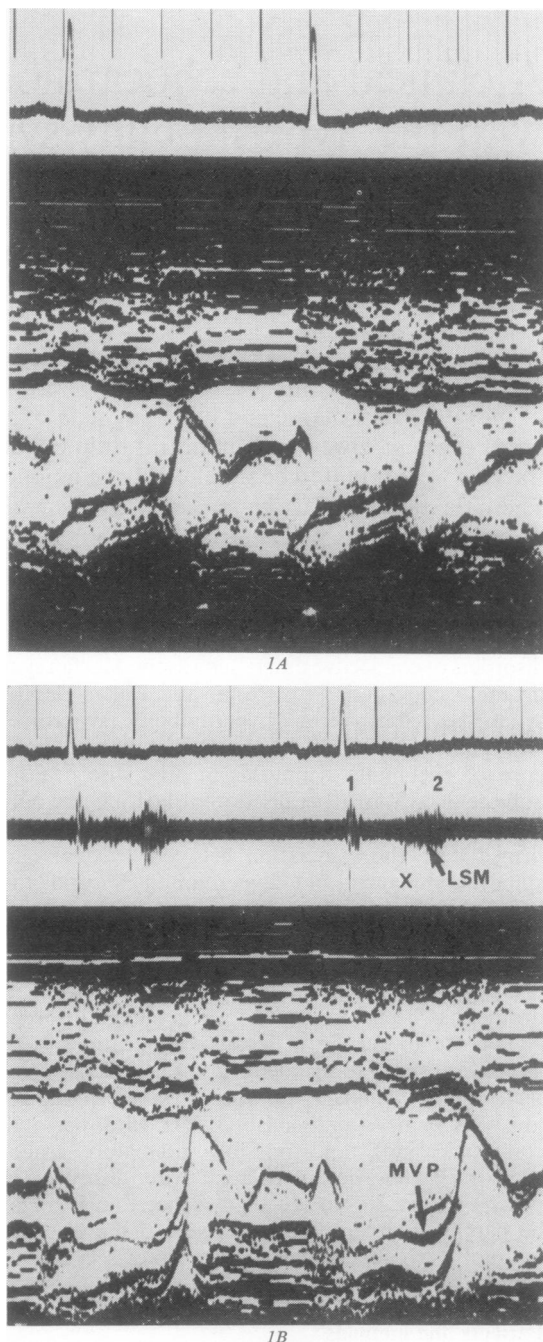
A*, a normal mitral echogram and, *B* an echocardiogram from one of our hypermobile patients with MVP, seen as abrupt posterior movement of the mitral echo in mid systole. The mid systolic click (*x*) and late systolic murmur (LSM) are shown on the simultaneous phonocardiogram.
